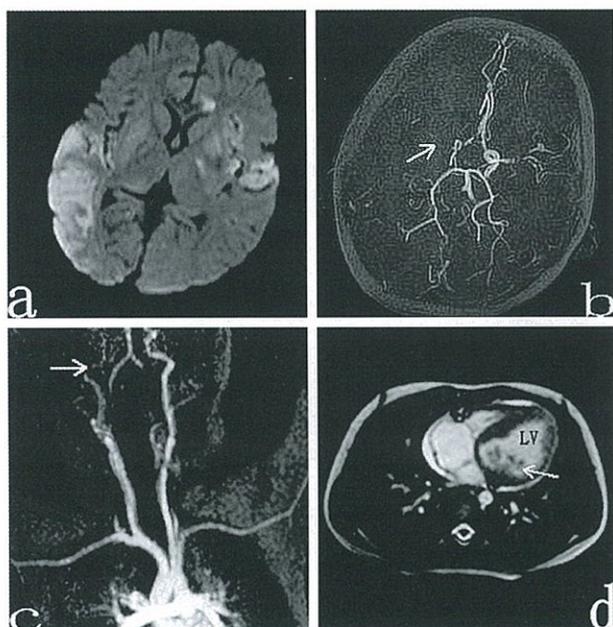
a: Abnormal signals in the temporal, occipital, and parietal lobes, and in the basal ganglia (MRI). b: Occlusion in the right middle cerebral artery (MRA). c: Occlusion in the right internal carotid artery (MRA). d: Abnormal signal in the left ventricle (Heart MRA).
